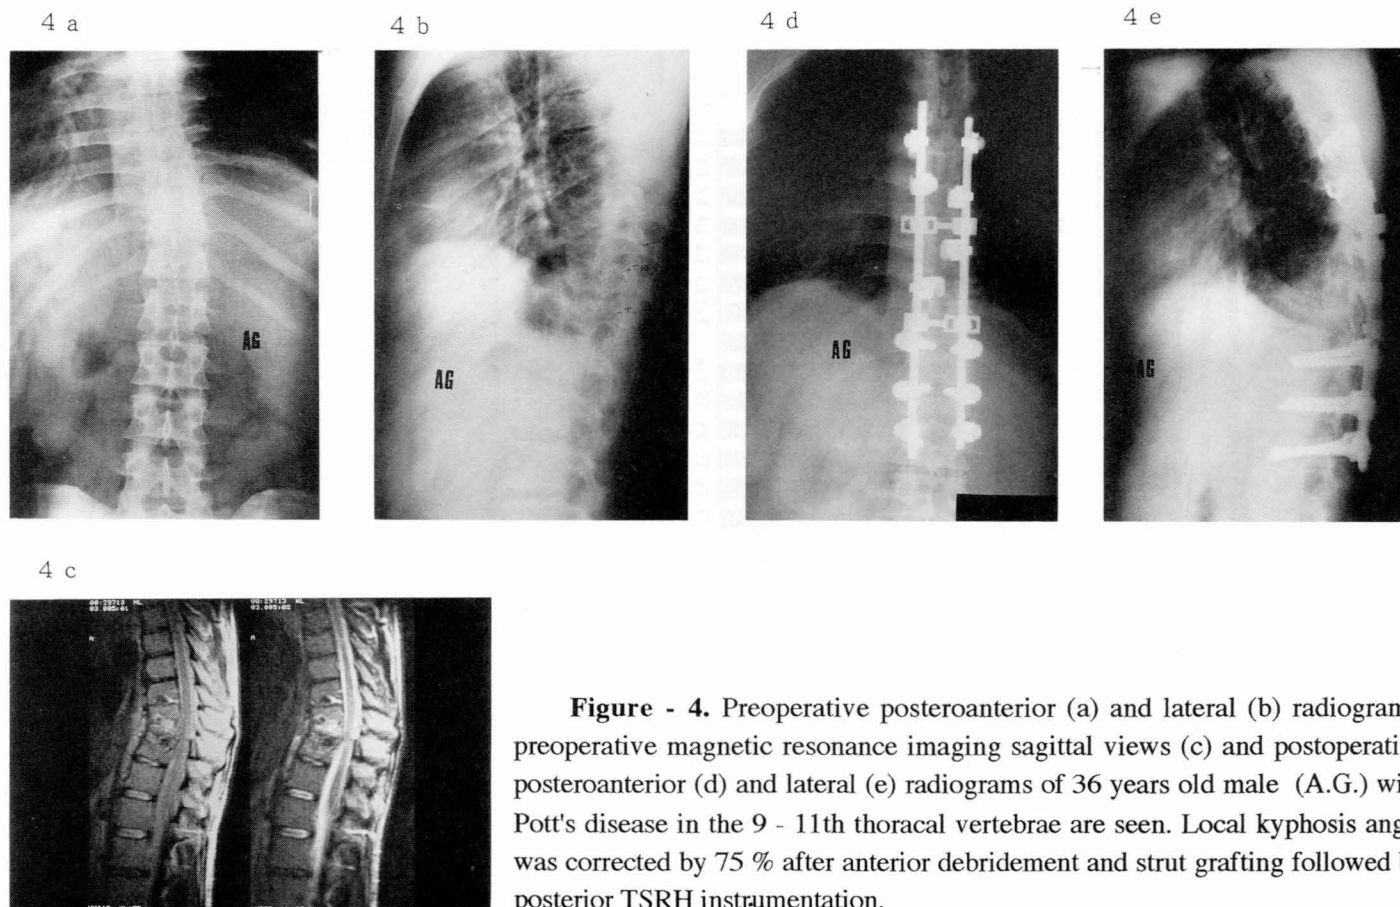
Preoperative posteroanterior (a) and lateral (b) radiographs, preoperative magnetic resonance imaging sagittal views (c) and postoperative posteroanterior (d) and lateral (e) radiographs of 36 years old male (A.G.) with Pott's disease in the 9 - 11th thoracal vertebrae are seen. Local kyphosis angle was corrected by 75 % after anterior debridement and strut grafting followed by posterior TSRH instrumentation.
